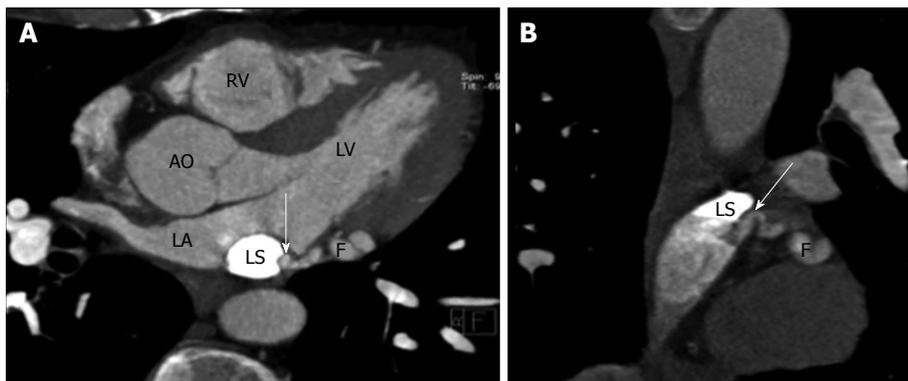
Left circumflex coronary artery to persistent left superior vena cava fistula. A: Axial coronary computed tomography angiography (CTA) image shows a fistulous connection (F) between left circumflex artery and a persistent left left circumflex coronary artery (LS) which eventually drained into the coronary sinus; B: Sagittal coronary CTA reconstructed images shows fistula (arrow) between the left circumflex artery and persistent left superior vena cava (LS). AO: Aorta; LA: Left atrium.
